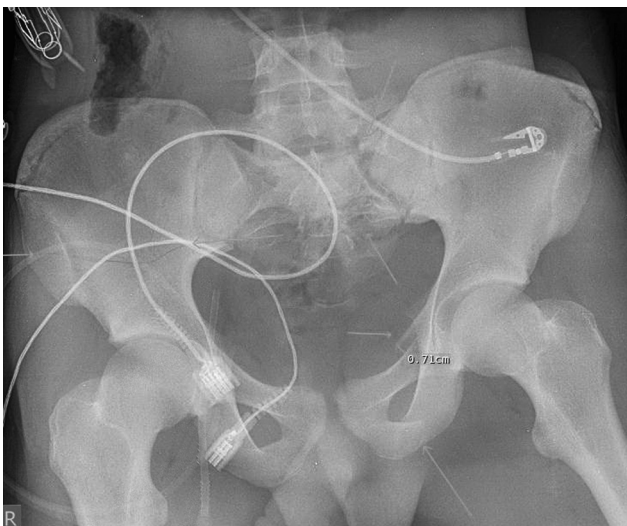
Case 2: Initial anteroposterior pelvis X-rays showing vertically unstable L pelvis with left L5/S1 facet fracture/dislocation.
